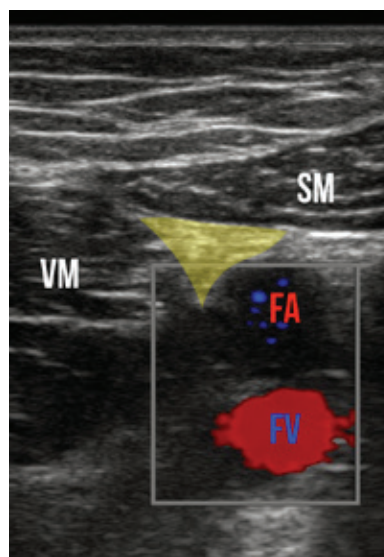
Color Doppler flow visualized in the femoral artery and vein. The target saphenous nerve is marked in yellow.
